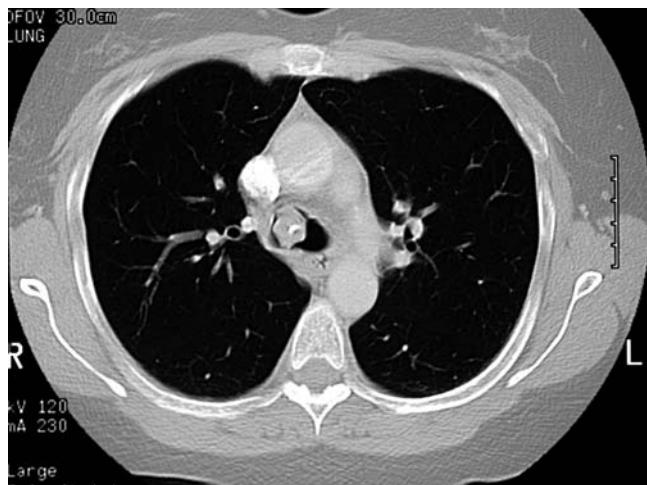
CT image showing a sessile endotracheal mass with air menisci on both sides. The mass lies just superior to the tracheal bifurcation (Courtesy of Dr. L. Pasillio, Northampton, MA).
